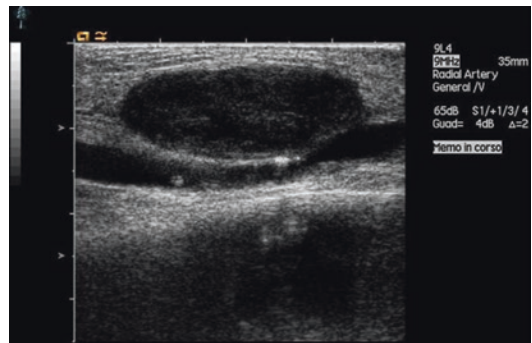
Early detection of hematoma secondary to incorrect venipuncture. AVF provides vascular access for hemodialysis allowing repeated needle insertions. Bleeding from the AVF with development of hematoma is a frequent complication which can be easily detected by ultrasound. Echo guide can also help in the correct cannulation in case of hematoma surrounding the vessel
